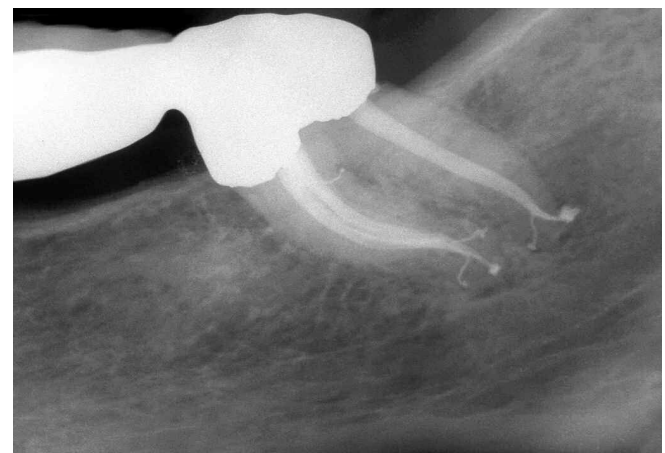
This radiographic image demonstrates provisionalization, flowing shapes, and filled multiple portals of exit.
